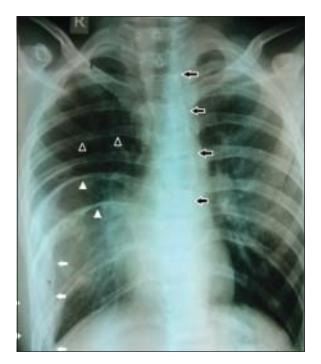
Chest x-ray postero-anterior view showing scoliosis (black arrows), extrathoracic soft tissue shadow with invasion of the pleural space (white arrows), consistent with plexiform neurofibroma, rib notching (black arrow-heads) and "twisted-ribbon" ribs (white arrow-heads)*
